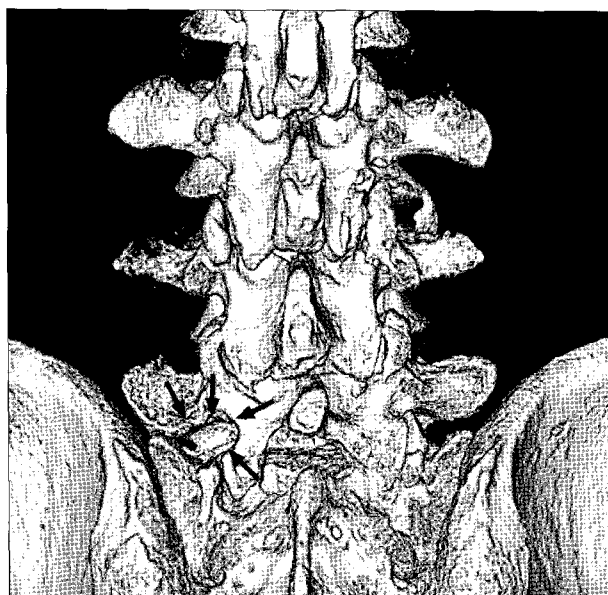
Postoperative computed tomographic image of a 62-year-old man with severe left leg pain. Three-dimensional reconstruction image shows the bony resected area of lateral isthmus and superolateral portion of facet joint (arrows). A portion of left S1 lamina is also resected.
